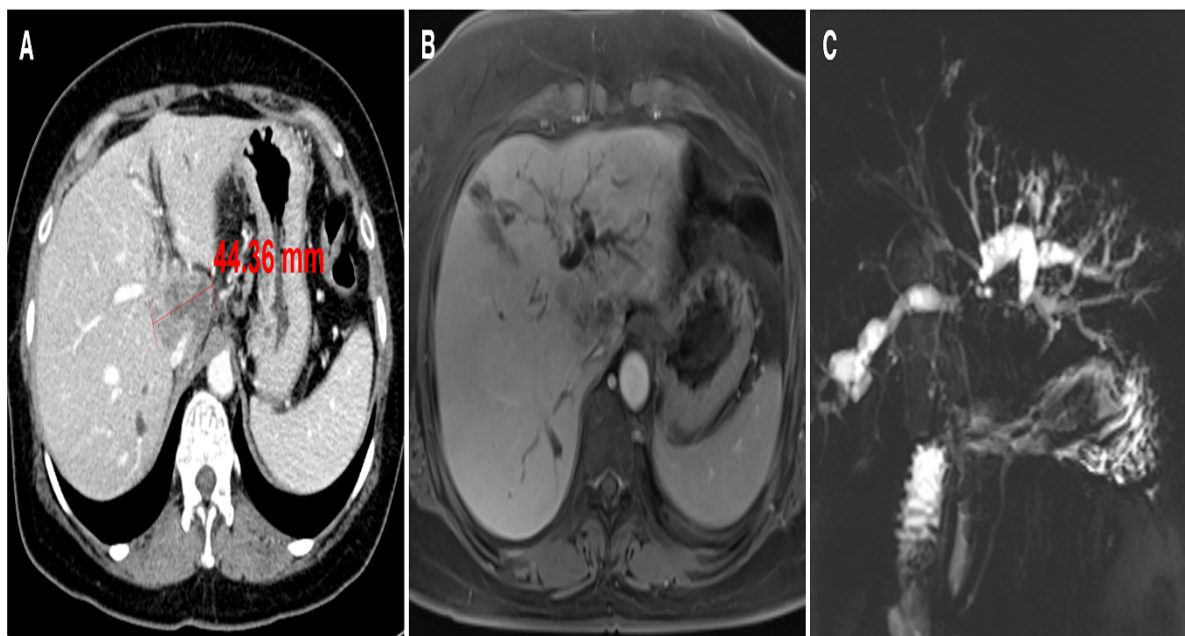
Preoperative images. Computed tomography showing a 4.4 cm solitary tumor in the caudate lobe extending to the hepatic hilum (a). Magnetic resonance cholangiography revealing severe dilatation of bilateral intrahepatic ducts (b) and cancer invasion to the second order branches of both bile ducts (c).
